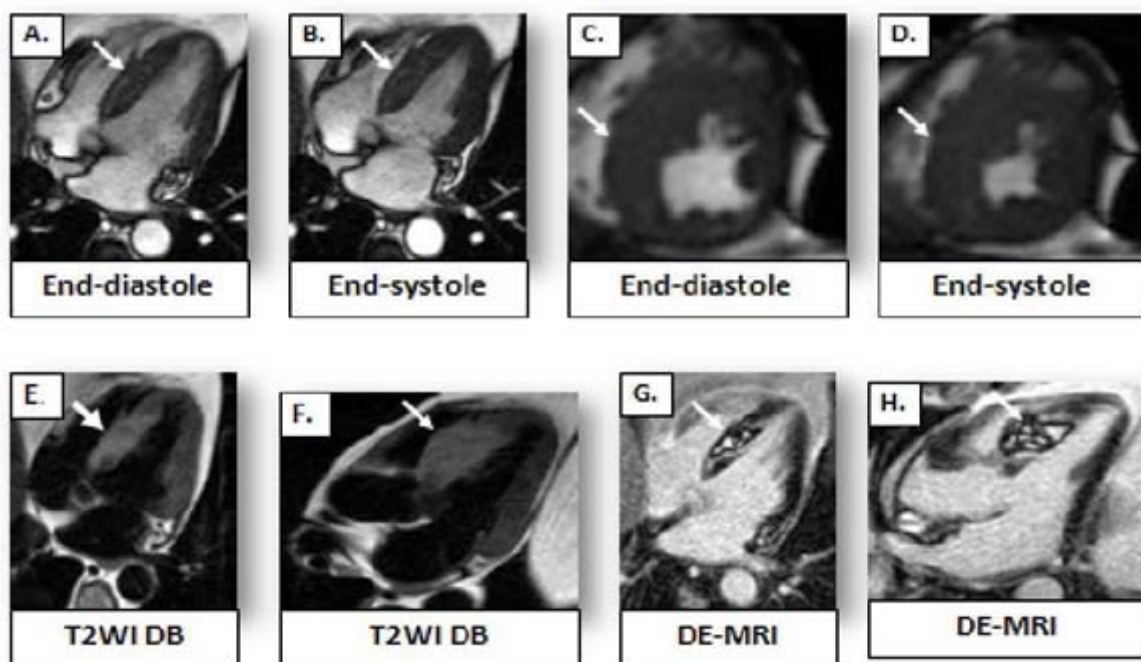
61-year-old man with no known coronary artery disease who presented with STEMI status post-catheterization with patent coronary arteries. He was diagnosed with large B cell lymphoma status post-high-dose of 5-fluorouracil and cyclophosphamide. Cine MRI, using white blood cell technique of 4 chamber (A, B) and midventricular short-axis slice (C, D). T2-weighted dark blood images (T2WI DB) and delayed enhancement (DE-MRI) of 4-chamber (E, G), and 3-chamber (F, H) views demonstrated wall thickening, hypokinesia, edema, hemorrhage, and delayed enhancement throughout the entire interventricular septum (arrows).
